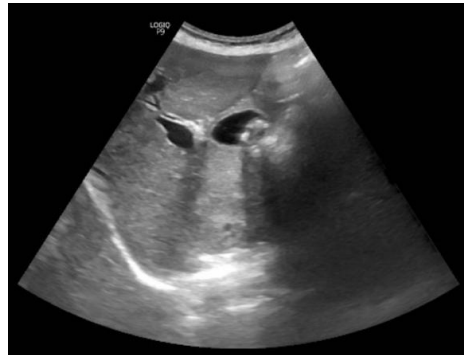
Abdominal ultrasound showed multiple stones.
